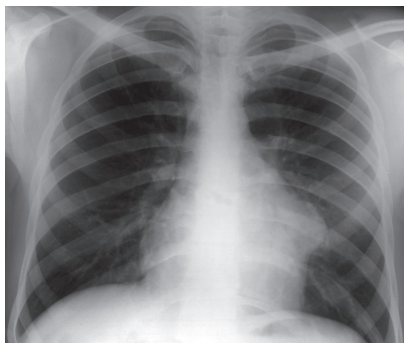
Frontal X-ray. Local expansion of the heart silhouette due to exocardiac tumor
